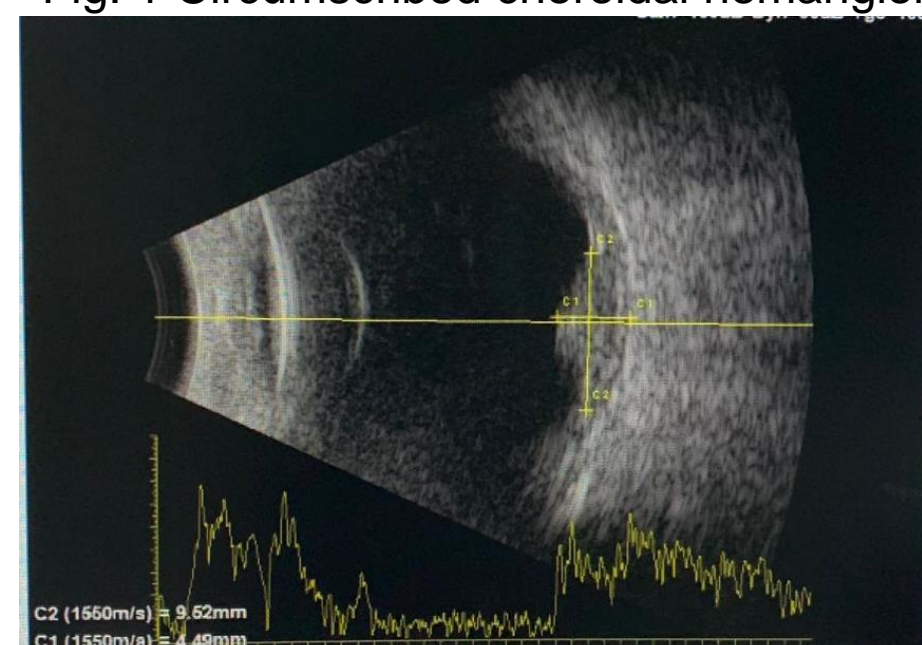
Ultrasonography shows a highly reflective lesion
